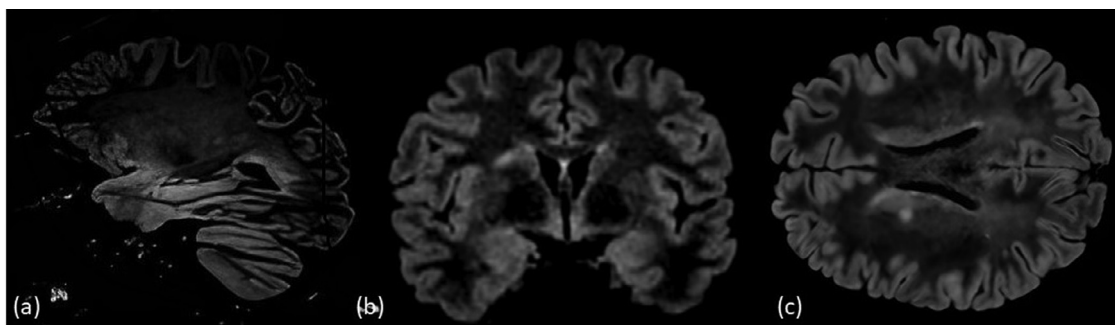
The T2-weighted images shows two hyperintense lesions in the right corona radiata (a, b) and left trigone of the lateral ventricle (c).
